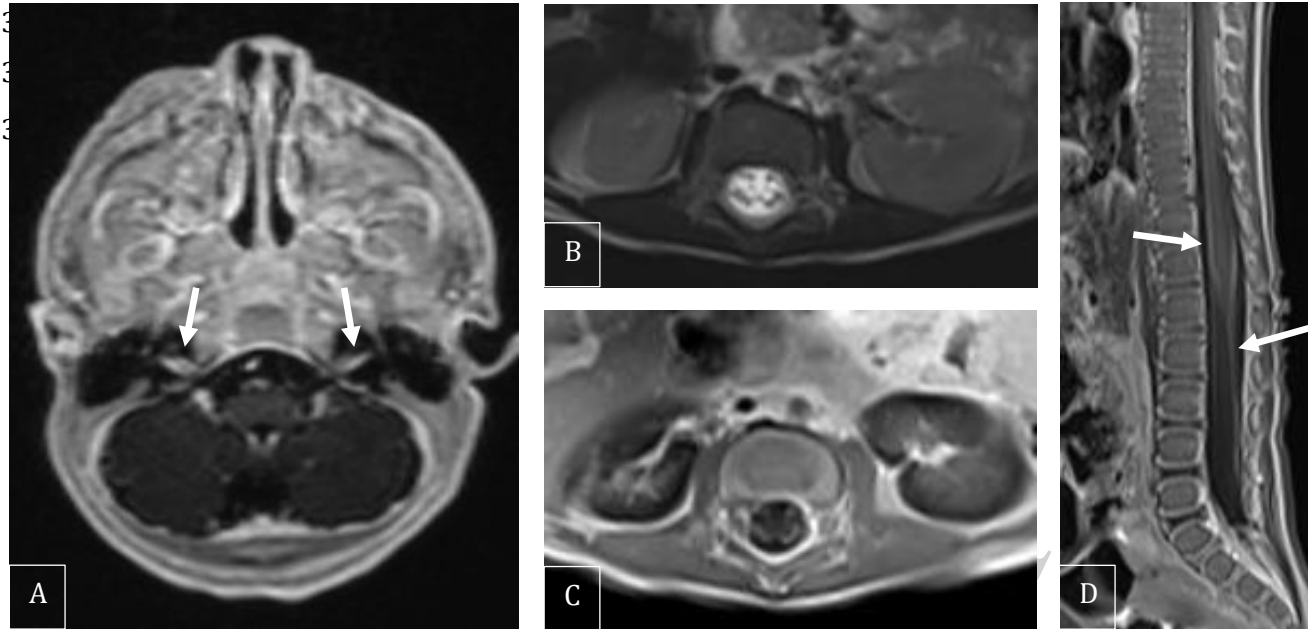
(A) A gadolinium-enhanced axial T1-weighted image through the posterior fossa shows bilateral enhancement in the internal auditory canals (arrows). (B) An axial T2-weighted image of the lumbar spine doesn't show abnormal thickening of the cauda equina nerve roots. There is however uniform enhancement of the spinal nerve roots on gadolinium-enhanced axial T1-weighted image (C). (D) The enhancement on the surface of the distal cord and cauda equina nerve roots is also shown on sagittal post-contrast T1 weighted image (arrows).
